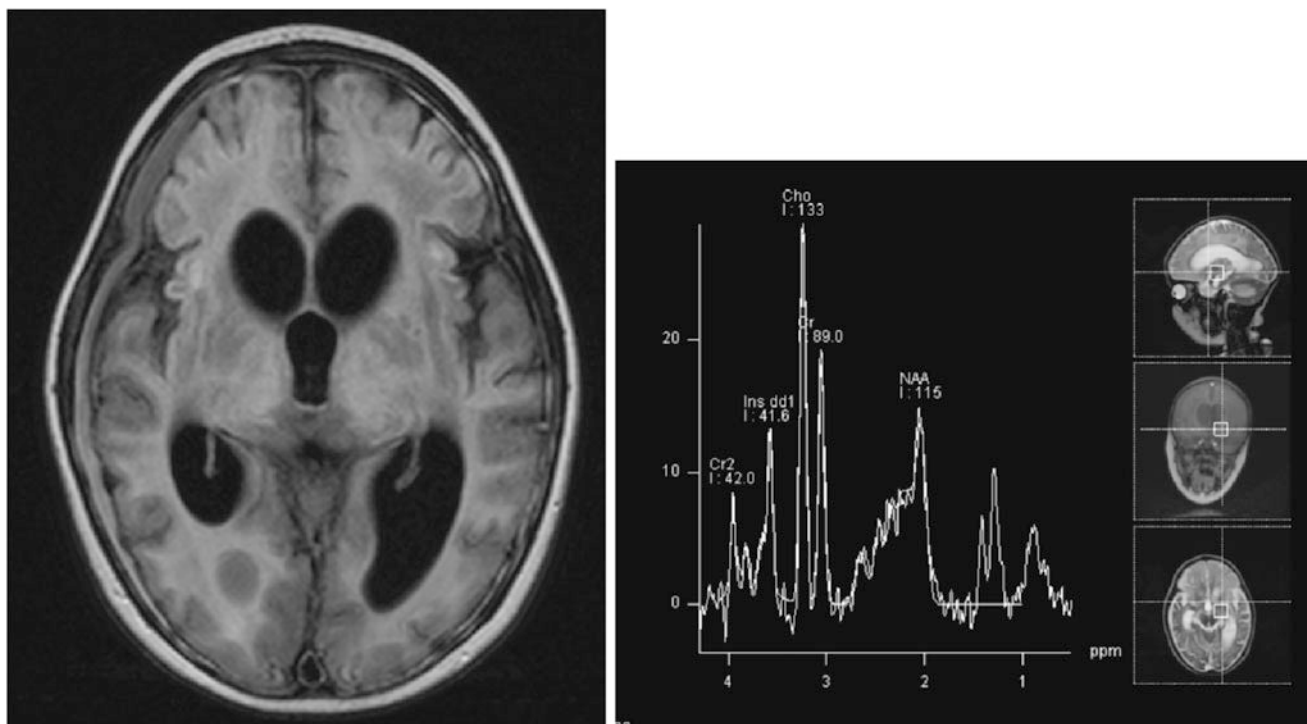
Brain MRI 30 days after onset showing progression of cortical changes with laminar necrosis
